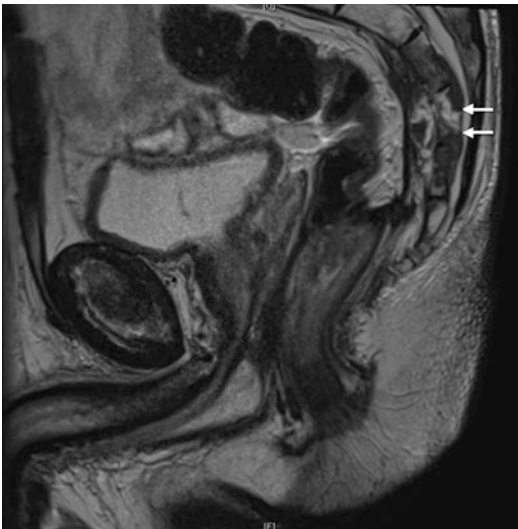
MRI demonstrating sacral recurrence (arrows) extending up to the level of S3
